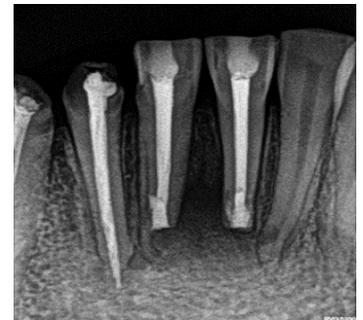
1 Month post op radiograph
